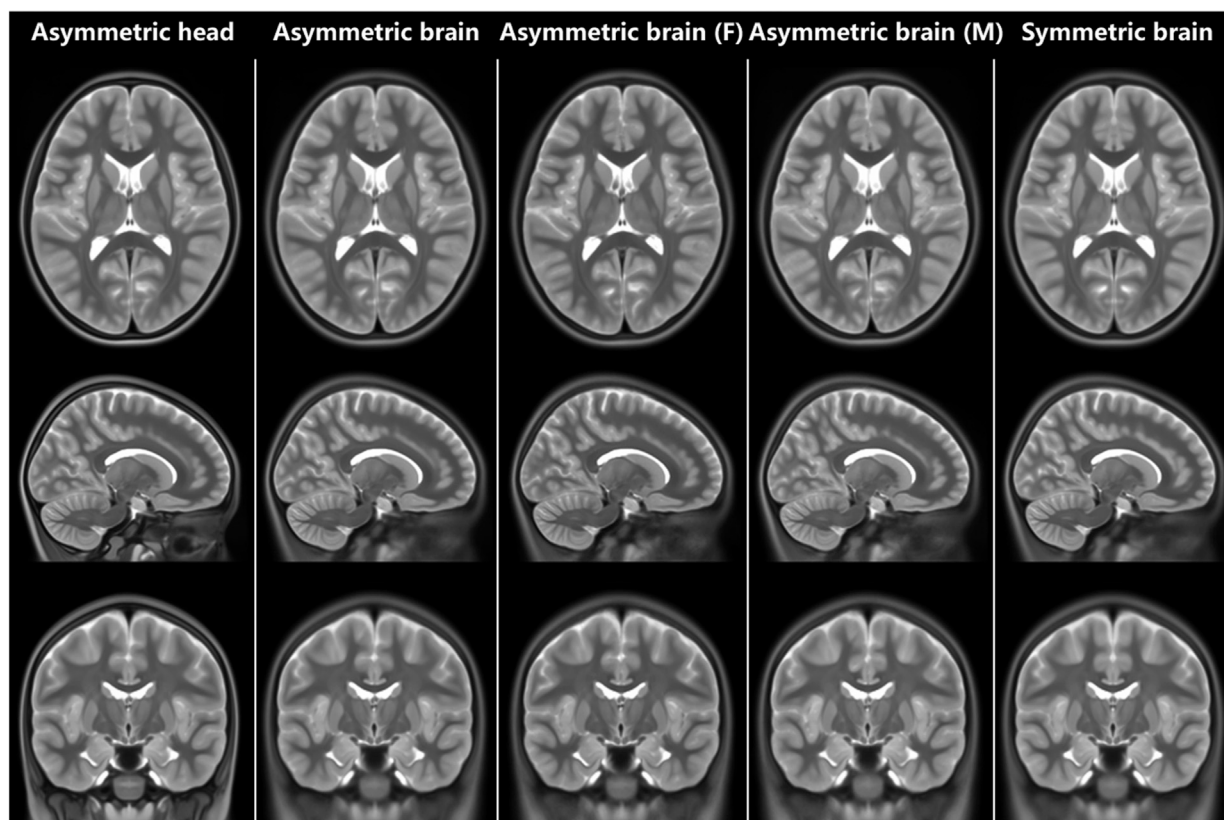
Detailed slices of the T2-weighted Chinese pediatric atlases at a full age range (6–12 years old). These templates include the asymmetric head/brain templates, asymmetric sex-specific brain templates (F, female; M, male) and the symmetric brain template. The templates are displayed in the neurological convention.
